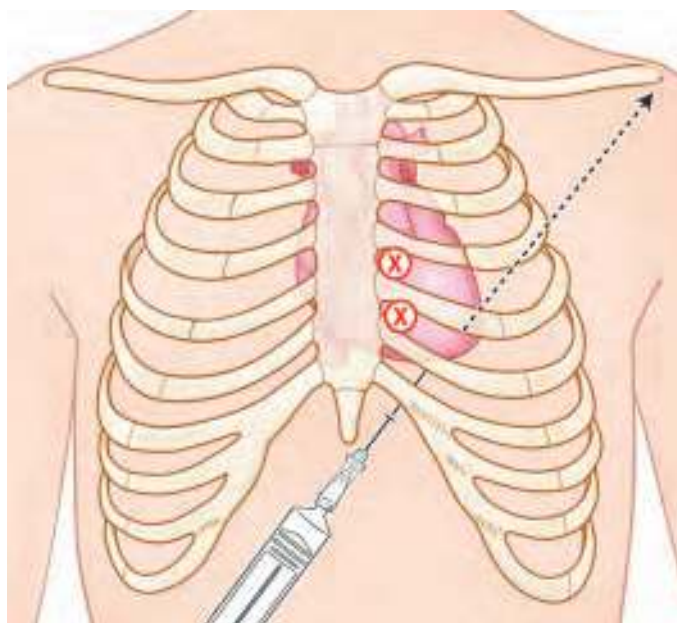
Intracardiac injection. The needle is inserted 1 cm to the left of the xiphoid process and aimed toward the left shoulder. The needle may also be inserted parasternally in the left fourth or fifth intercostal space (as denoted by the X).
